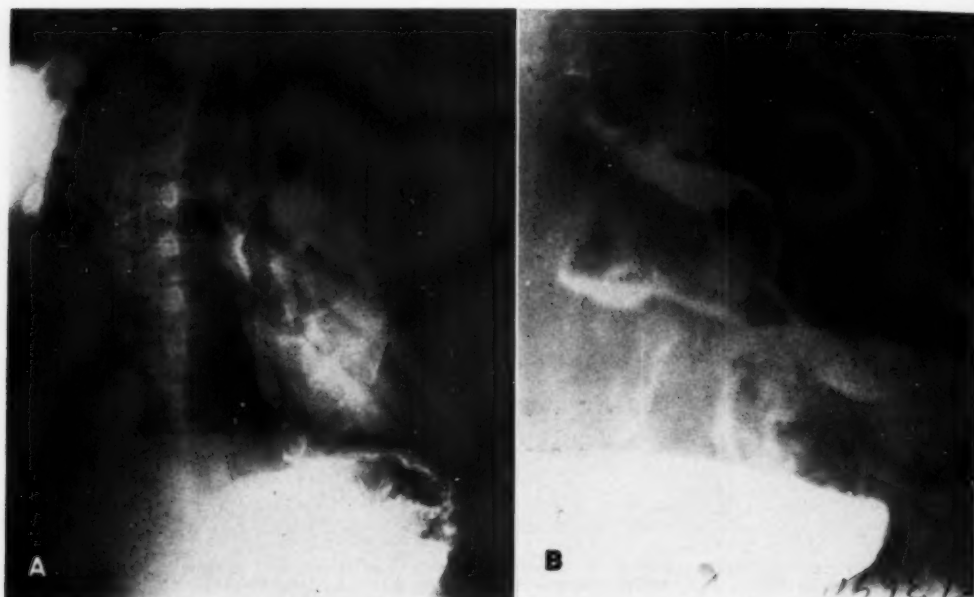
Paracardial and left gastric artery lymph nodes. A 62-year-old white male entered the hospital two months after the onset of dysphagia. The roentgen examination disclosed the presence of a tumor beginning at the superior margin of the aortic arch and extending downward for a distance of 9 cm. The right anterior oblique roentgenogram (A) shows the primary tumor (solid arrows) accompanied by enlargement of the bifurcation lymph nodes. A right anterior oblique projection centered over the fundus of the stomach in the upright position (B) shows a nodular indentation along the lesser curvature of the stomach just below the cardia due to enlargement of the paracardial and left gastric artery lymph nodes (dotted arrows).
